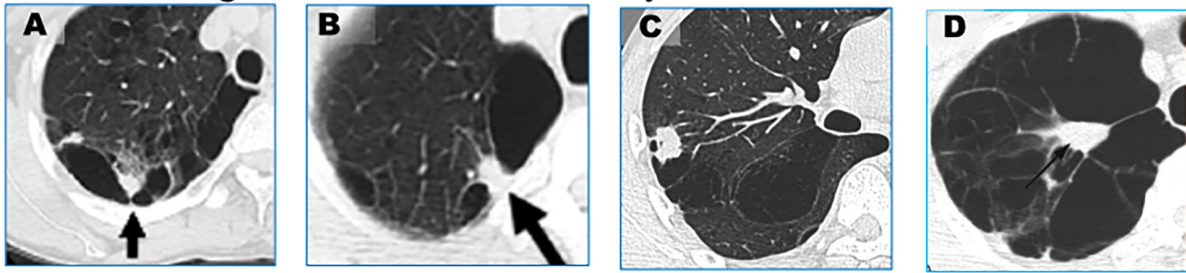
Representative CT images of cavitary LCAL.
